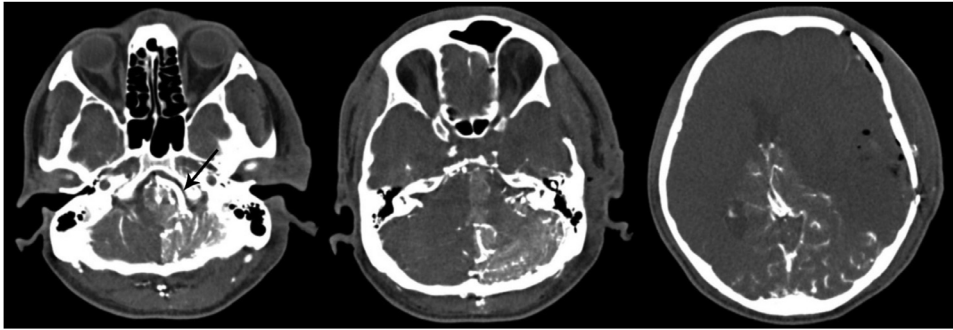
“Arterial phase” of CTA showed enhancement of the left distal vertebral artery (arrow), left PICA territory, left cerebellar hemisphere, basilar artery, right AICA and SCA territories, and bilateral PCA territories.
